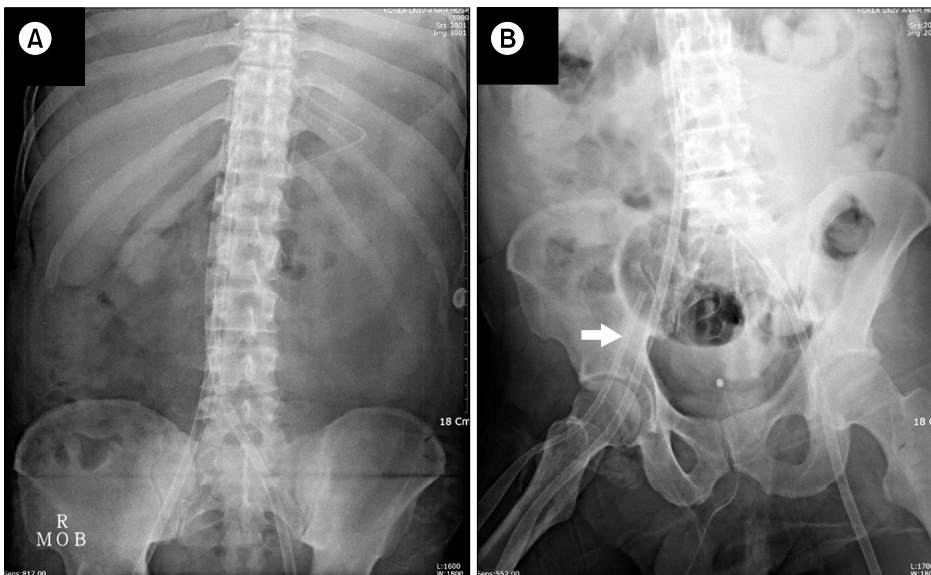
Abdominal X-ray. Multi-hole 21-Fr long femoral venous cannula (Biomedicus) in both femoral arteries. (A) The right femoral cannula was used for inflow. (B) The newly inserted 17-Fr femoral arterial cannula (Biomedicus, white arrow) was used for venoarteriovenous mode in the right femoral artery.
